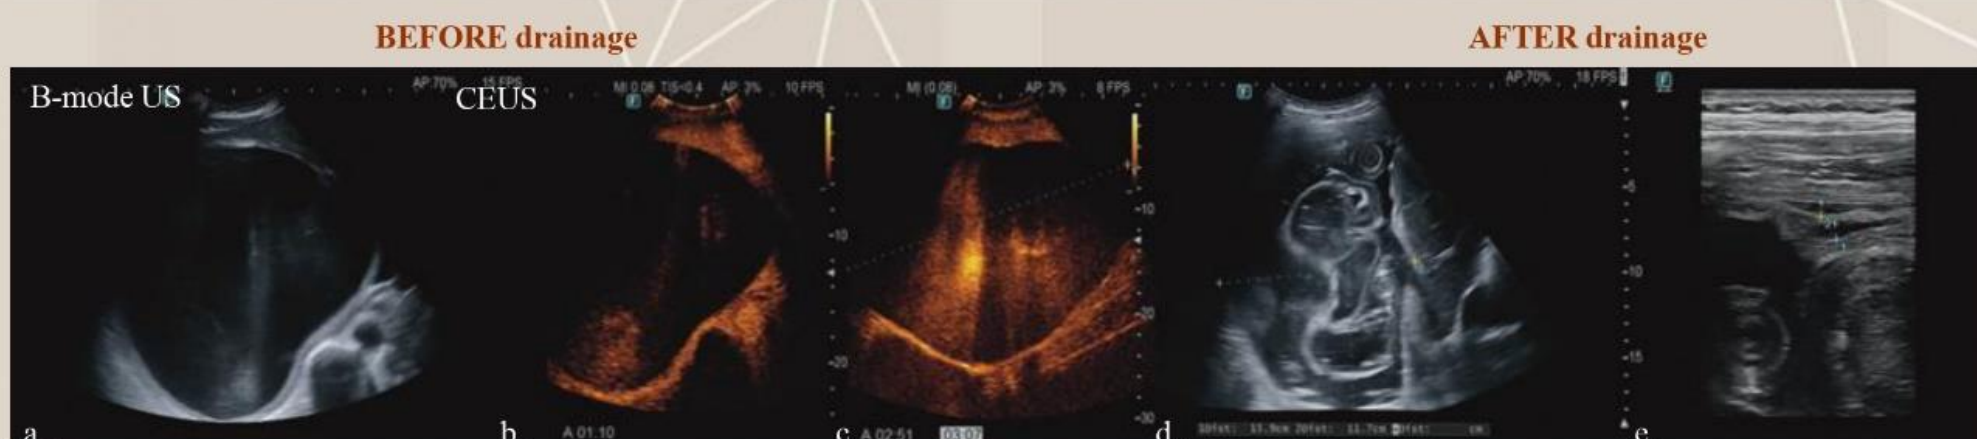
B-mode US showed a giant cyst (30 cm long axis) located in right liver lobe, with a thin and regular wall but inhomogeneous fluid content (suspected protein or hemorrhagic fluid). CEUS revealed non-enhancement of the wall and confirmed the inhomogeneity of the fluid content. After drainage: cystic lesion with daughter lesions as stage 3 according to Gharbi ultrasound classification.
